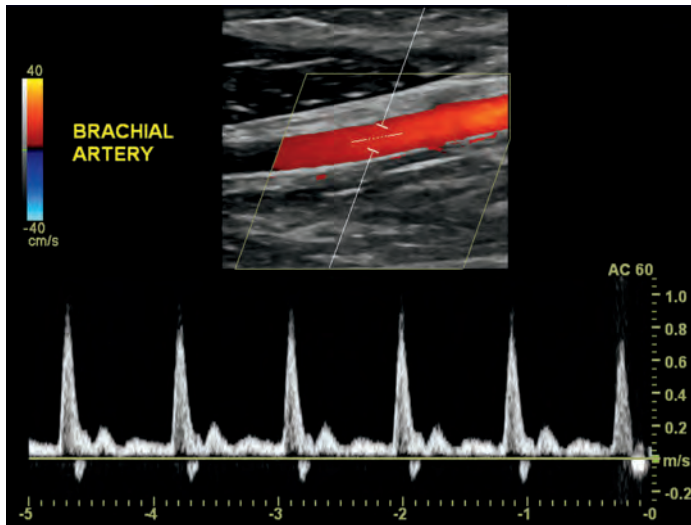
Spectral Doppler of the brachial artery, accompanied by color flow. Courtesy of Steve Bernhardt, BS, RDMS, RVT, RPhS.
